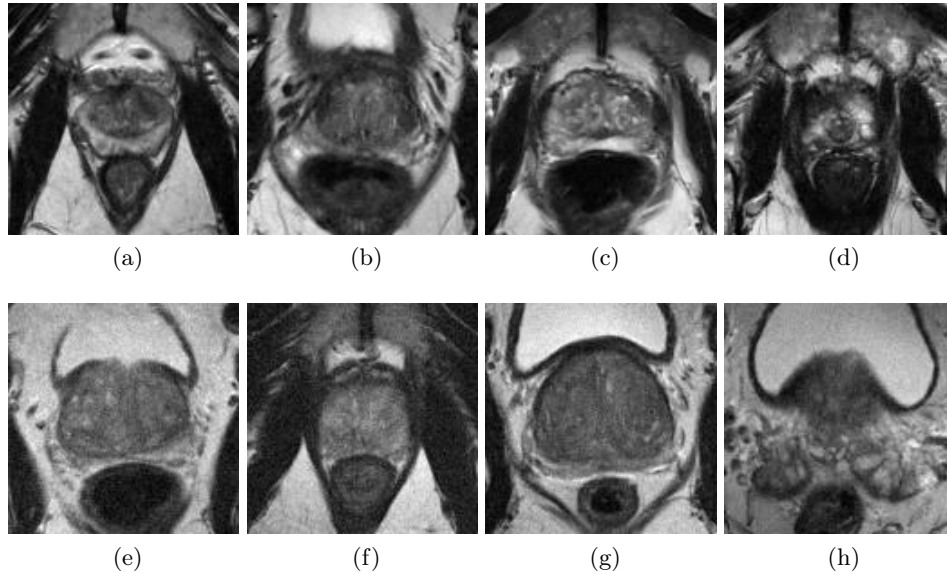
Examples of real and synthetic MRI images of prostate cancer categorized by ISUP grade. (a) ISUP 2 real image; (b) ISUP 3 real image; (c) ISUP 4 real image; (d) ISUP 5 real image; (e) ISUP 2 synthetic image; (f) ISUP 3 synthetic image; (g) ISUP 4 synthetic image; (h) ISUP 5 synthetic image.
